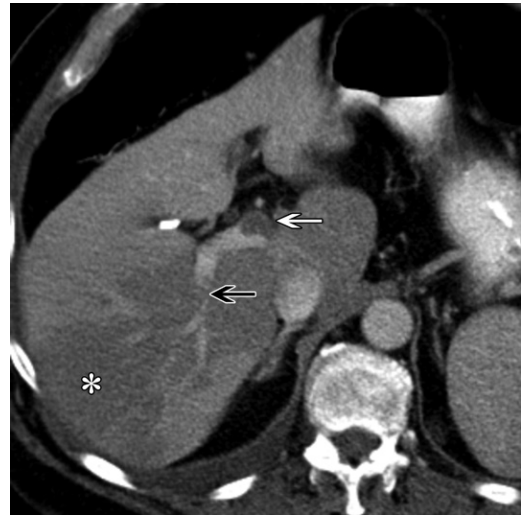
Portal vein thrombosis in a 59-year-old woman with chronic ulcerative colitis. Axial contrast-enhanced CT image shows partially obstructive thrombus (white arrow) within the main portal vein, with poorly organized thrombus (black arrow) in the posterior branch of the right portal vein. An area of geographic decreased attenuation (*) is seen within the posterior segment of the right hepatic lobe, a finding consistent with segmental hepatic steatosis from altered lipid metabolism in the setting of segmental portal vein thrombosis.
